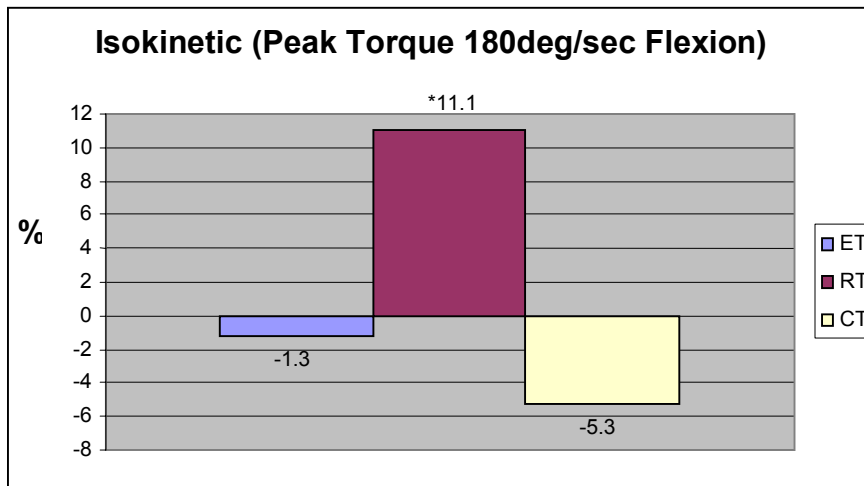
Percent changes in isokinetic peak torque during knee flexion at 180deg/sec from pre- to post-training. \* Significantly different from ET and CT changes. ( $P \leq .05$ )
